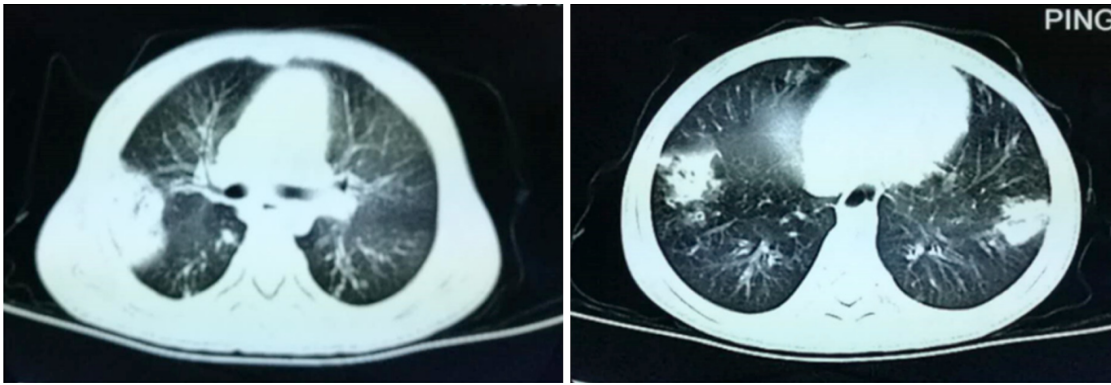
Chest computed tomography images of the cystic fibrosis patient. A chest computed tomography scan showed obvious exudative lesions and bilateral bronchiectasis in the lung of the cystic fibrosis patient.
